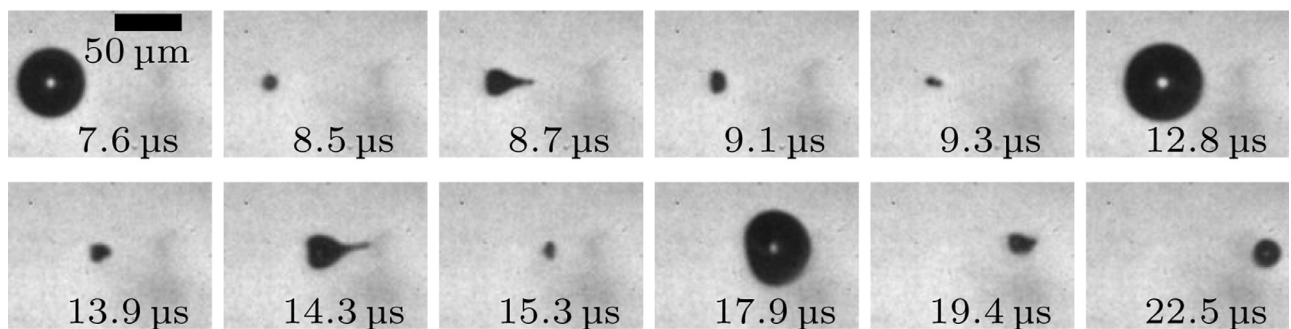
Representative images from a side view sequence of microbubble cavitation, aligned to the propagation axis, in response to a focused ultrasound burst with a peak negative pressure of 0.7 MPa.
